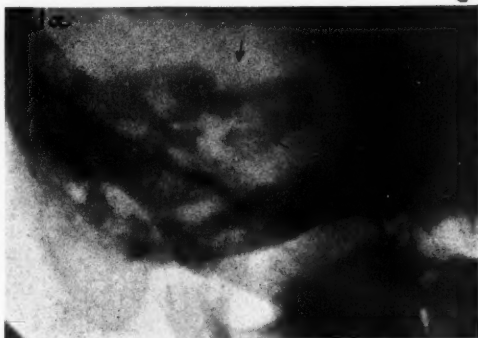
Roentgenogram of the temporal bone after the Stenvers method. A typical pressure erosion of the upper margin of the pyramid. Destruction of the cochlea and of the vestibule with anterior opening up of the internal auditory canal, caused by a sarcomatous endothelioma.
